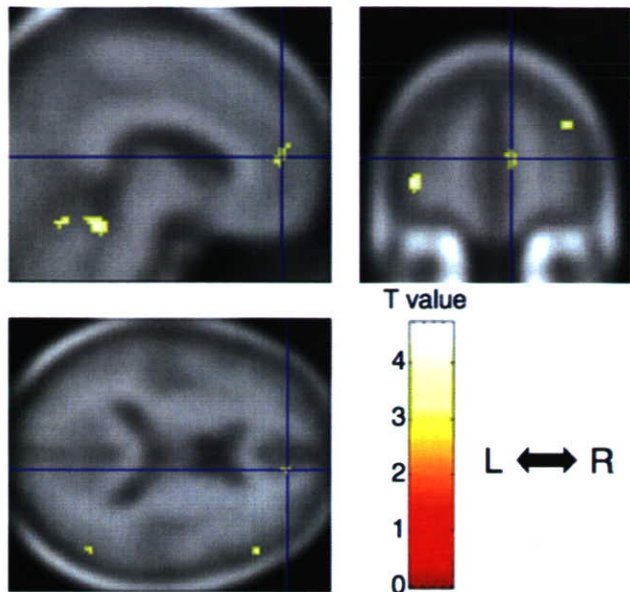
Brain region showing posttraumatic stress disorder Diagnosis × Combat Exposure interaction. Regional interaction for gray matter density in pregenual anterior cingulate cortex is rendered onto orthogonal slices of the averaged magnetic resonance image of the study subjects. Crosshairs indicate the peak coordinate of the interaction [8 50 12]. L, left hemisphere; R, right hemisphere.
